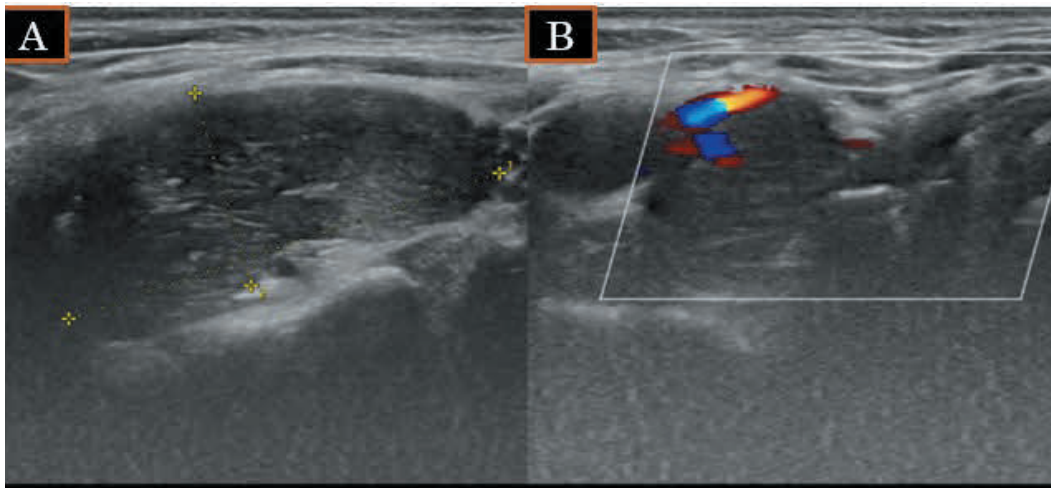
The grayscale (A) and color Doppler (B) ultrasound images demonstrated a hypoechoic mass that lay next to the common carotid artery’s inner border and hypervascularity
